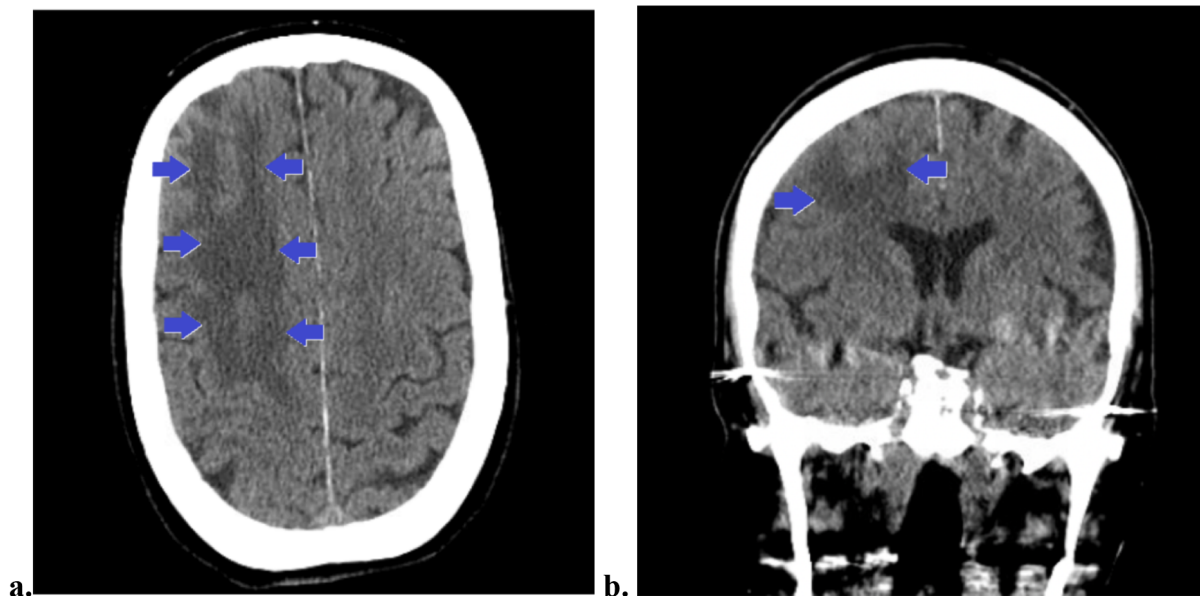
Axial view (a) and coronal view (b) of computed tomography of the brain showing right frontal hypodensities as indicated by the blue arrows.
